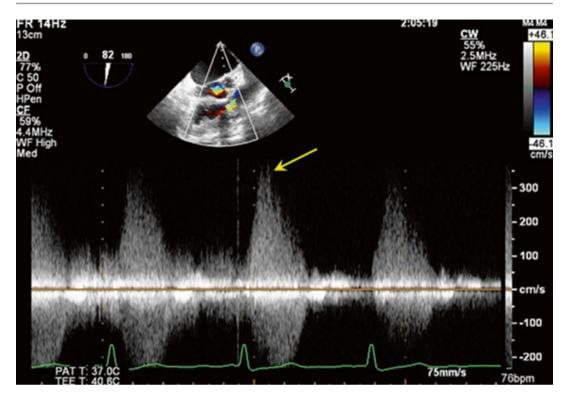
2D TEE continuous-wave Doppler, showed high-velocity pressure (*arrow*) at RV outflow tract due to infundibular pulmonic stenosis
